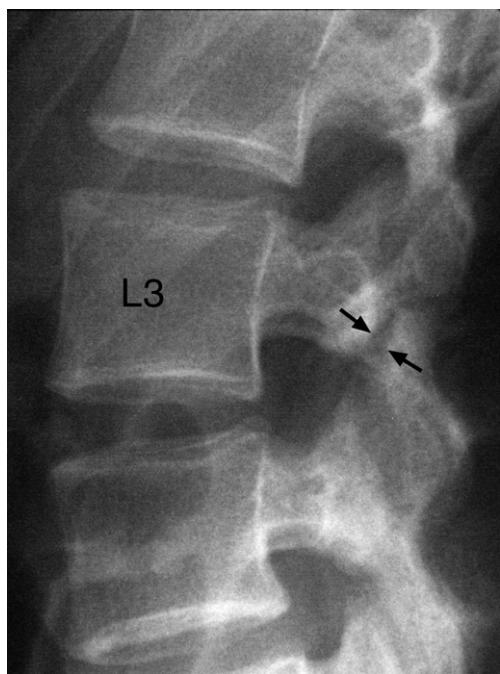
Lumbar spine lateral plain X-ray image. Note the pars interarticularis fracture at the L3 vertebral level (arrows).
